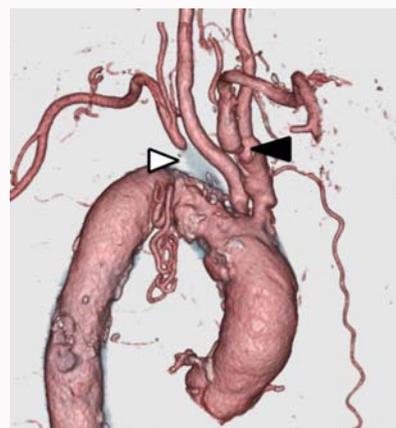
Preoperative computed tomography scan showing occlusion of the left subclavian artery (white arrowhead) and severe stenosis of the right subclavian artery (black arrowhead).
